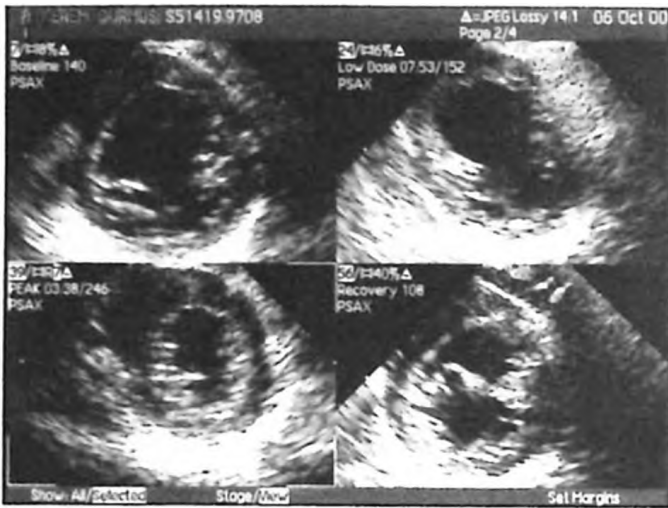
Dobutamine stress echocardiography parasternal short-axis views at the beginning of study, at low dose ( $5 \mu\text{g}/\text{kg}/\text{min}$ ) dobutamine infusion, at maximum dose ( $40 \mu\text{g}/\text{kg}/\text{min}$ ) infusion and at the end of recovery period. No wall motion abnormality can be seen.
